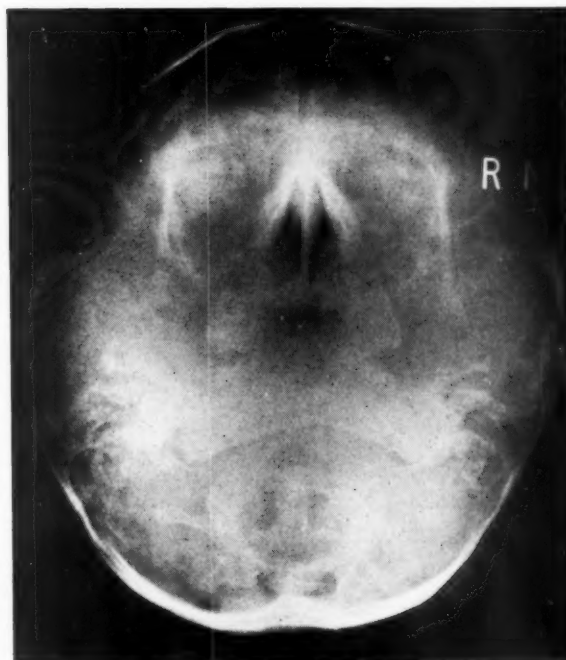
Case 2. Occipitomeatal radiograph.
